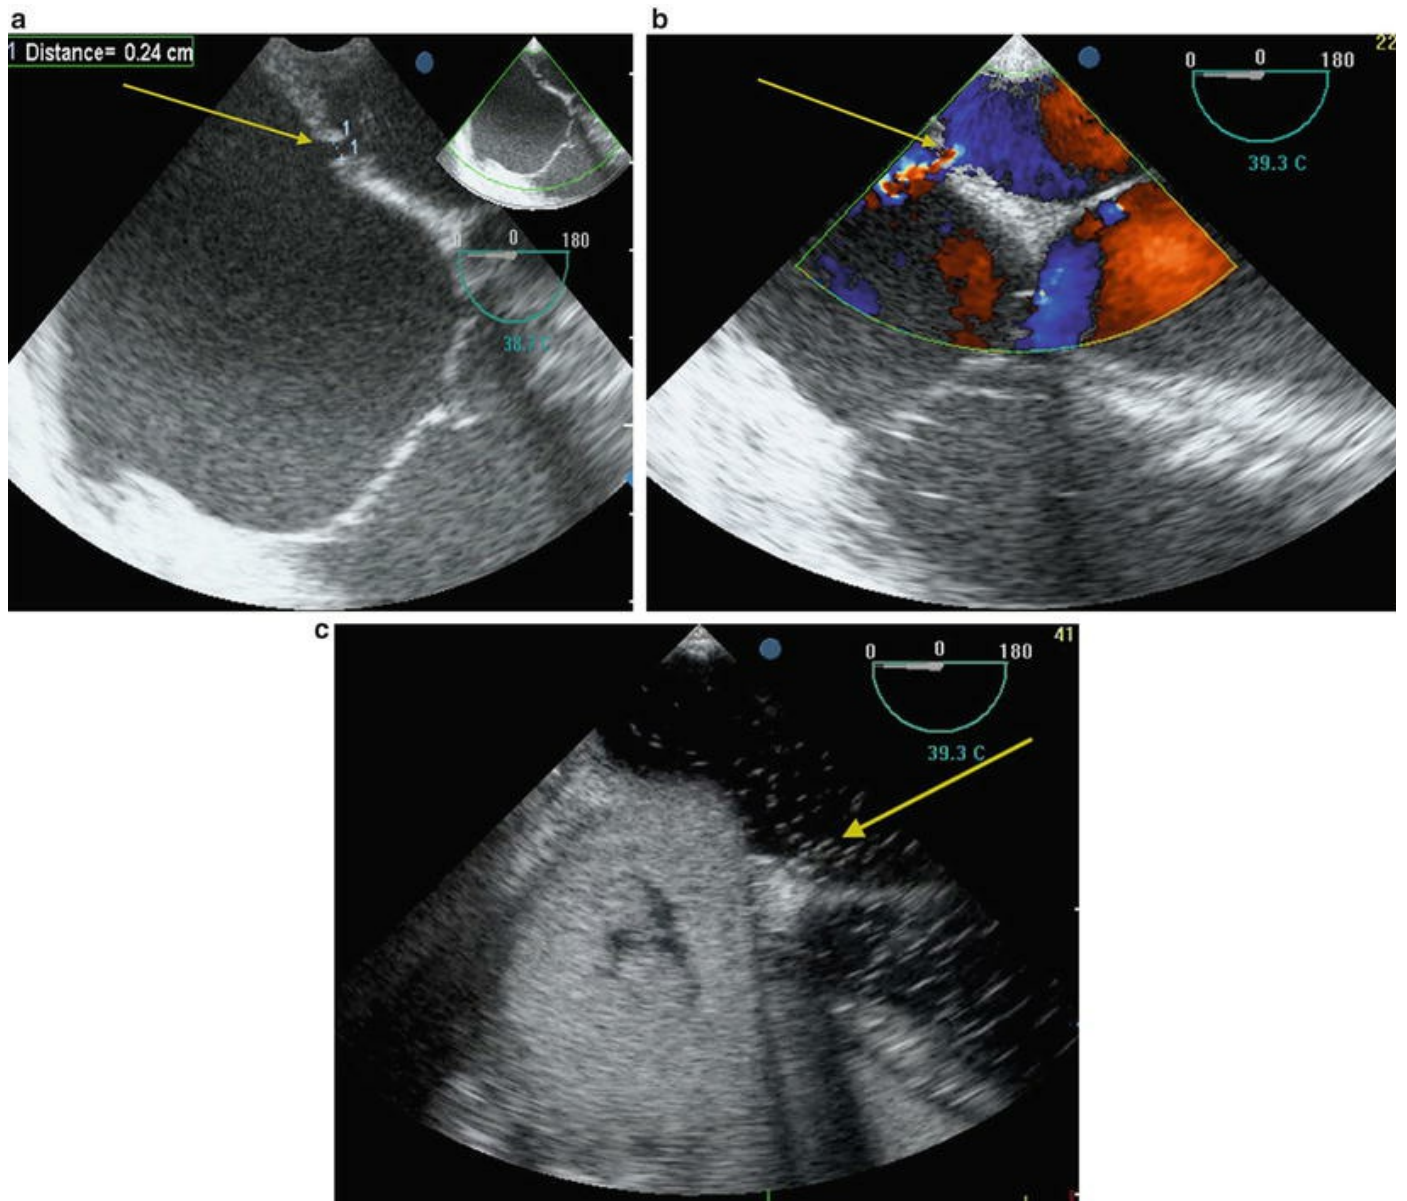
Echocardiographic demonstration of intracardiac shunt in a patient undergoing double lung transplantation . (a) Two-dimensional echocardiography showing atrial septal defect (*arrow*). (b) Color Doppler showing flow through atrial septal defect (*arrow*). (c) Positive bubble study with air in the left side cardiac chambers (*arrow*)
